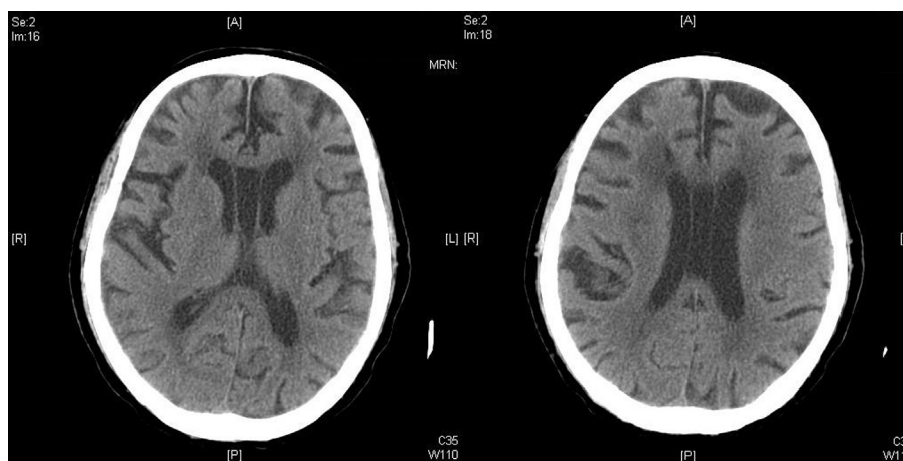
Axial plain computed tomography of the brain showing cavum septum pellucidum and cavum vergae.
